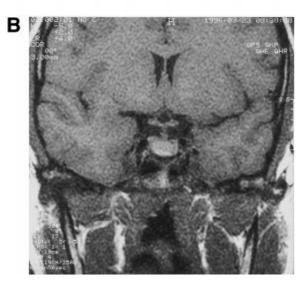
Magnetic resonance imaging with coronal sections of one example of macroprolactinoma (no. 29, Table 1) (A) before and (B) after six months treatment with quinagolide at a dose of 0·075–0·45 mg/day.
